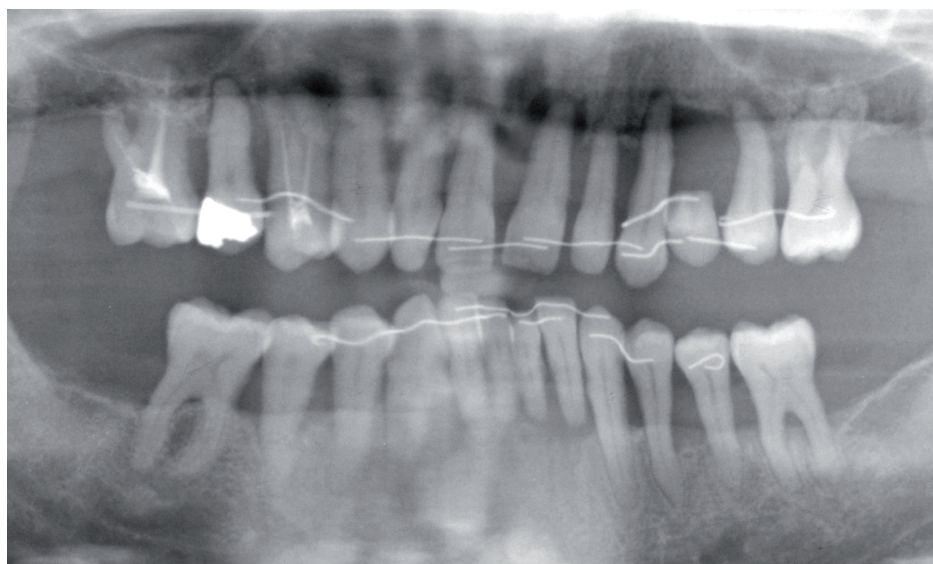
A: Lateral cephalogram before orthodontic treatment; B, C: Clinical situation at examination 4; D, E: Clinical situation during orthodontic treatment; F: Orthopantomogram at initial examination.
